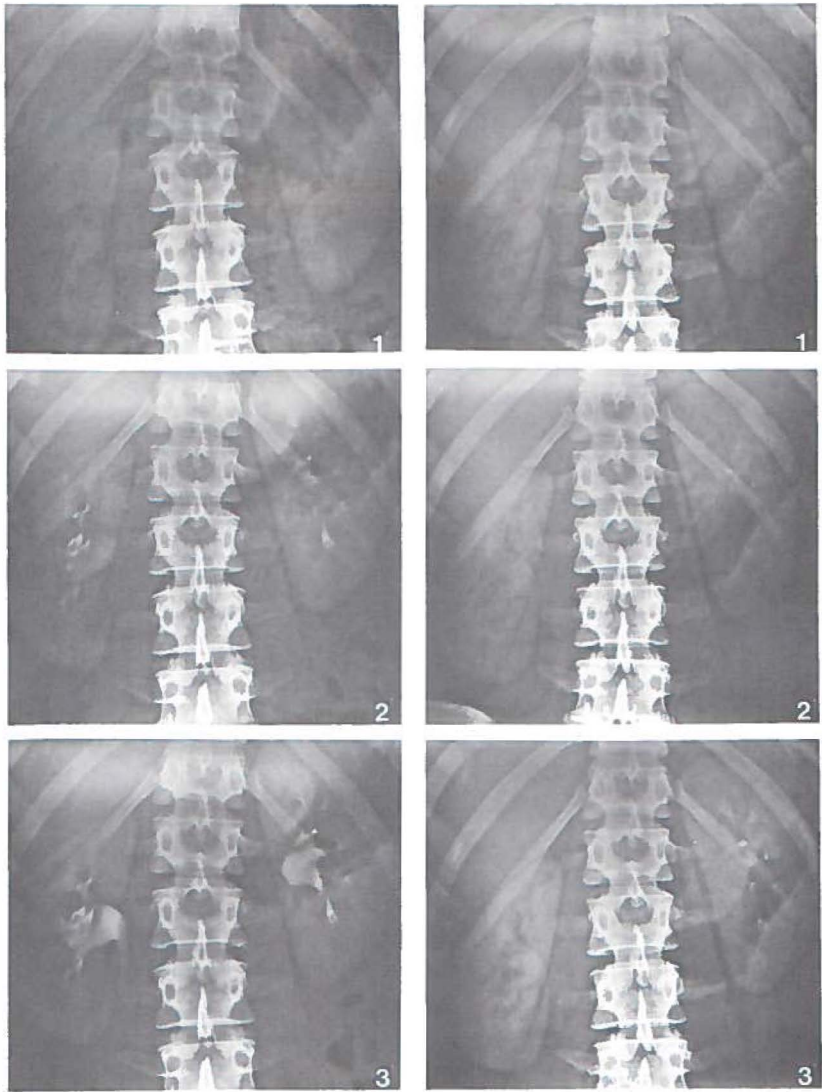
Rapid sequence IVU after three hours in supine position (left panel) and after three hours in upright position (right panel). The X-ray films were taken at 1, 2 and 3 minutes after injection of the contrast medium. For details see text.
